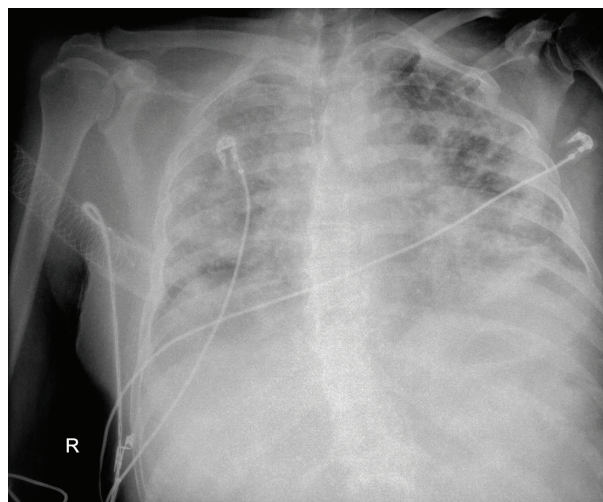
Chest x-ray on day 6 of Intensive Care Unit stay.
